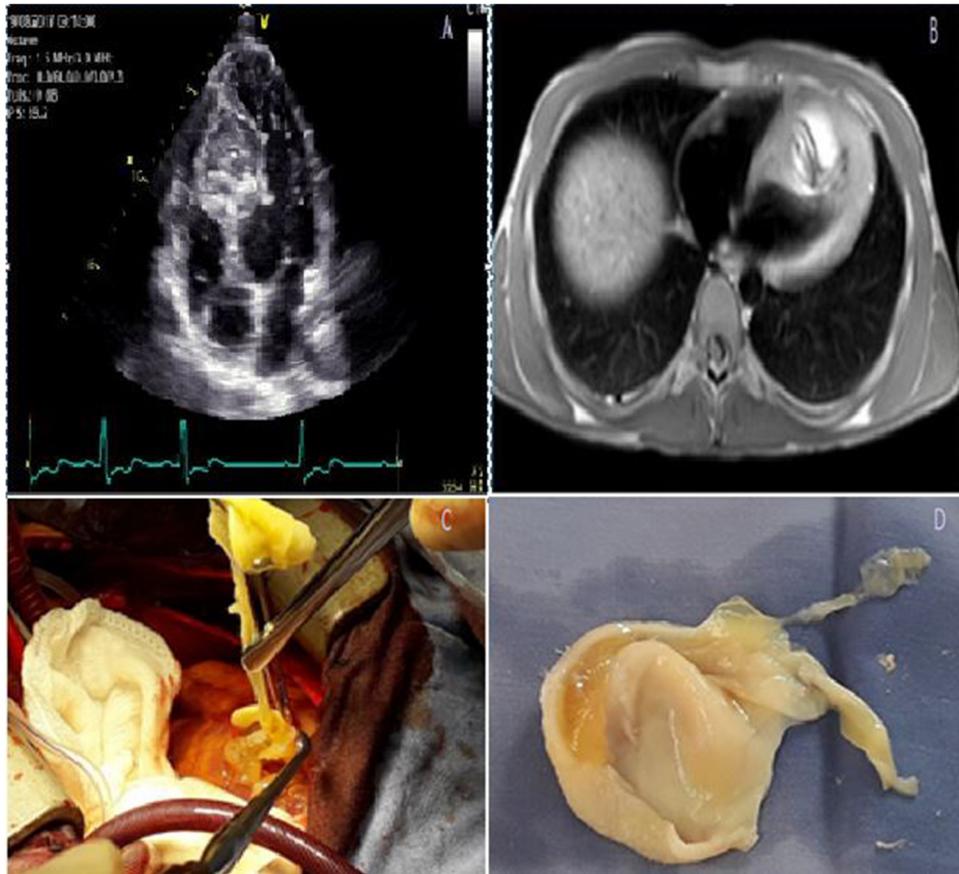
A: Echocardiographic frame in an apical 4-chamber view showing a large cystic mass splitting the interventricular septum. B: Magnetic resonance image showing hydatid cyst located in the interventricular septum. C: cystectomy and membrane extraction. D: germinative membrane.
